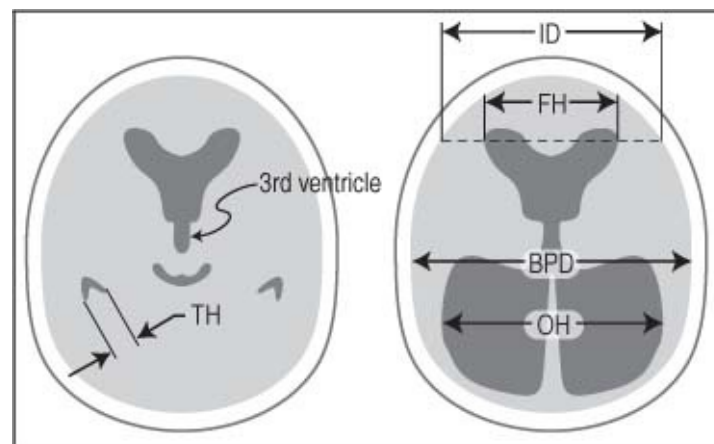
Linear ventricular measurement for CT, MRI or U/S Abbreviations: TH = temporal horns, FH = frontal horns, ID = internal diameter, BPD = biparietal diameter, OH = occipital horns
